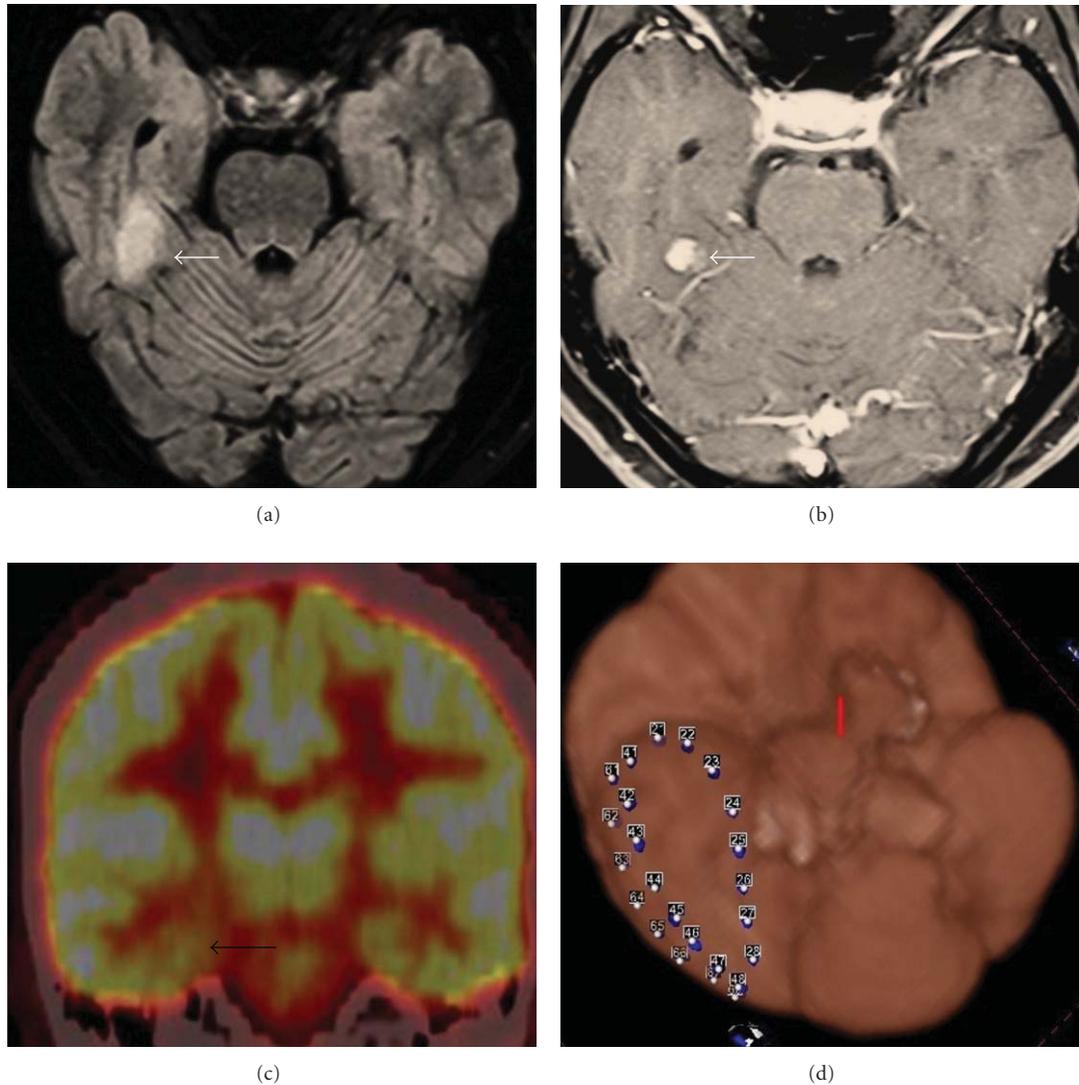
(Case 3) MRI of the brain ((a) FLAIR and (b) contrast) shows a right posterior temporal lesion that is enhanced with contrast injection. FDG-PET (c) scan shows mild right temporal hypometabolism. (d) Coregistered image of the location of the subdural lines during invasive monitoring (8 contacts and three strips; the image was obtained with Atamai Epilepsy Viewer software [6]).
